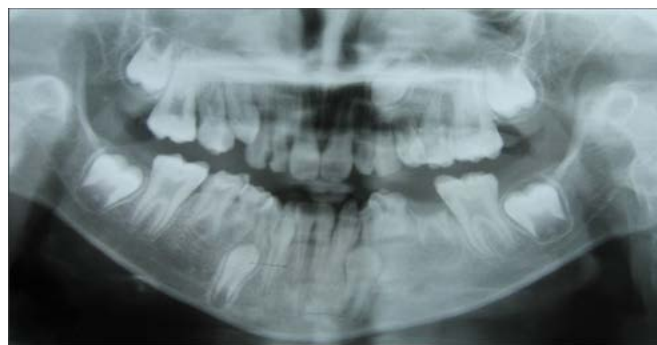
The radiographic appearance of the patient before dental treatment.
